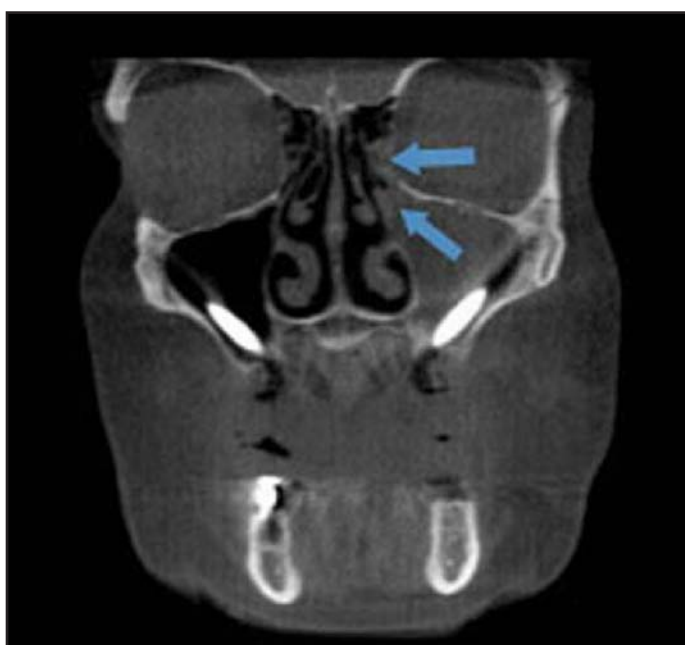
CBCT Image taken for follow-up evaluation. Image reveals opacification of the left maxillary sinus suggestive of chronic sinusitis of the left maxillary and ethmoidal sinuses.
